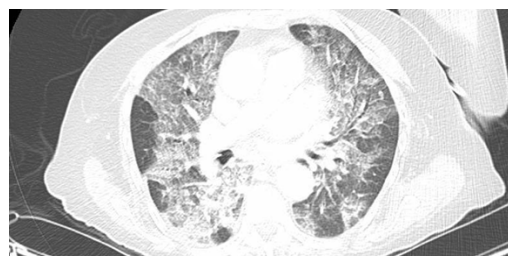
Computed tomography of the chest showing alveolar hemorrhage.
